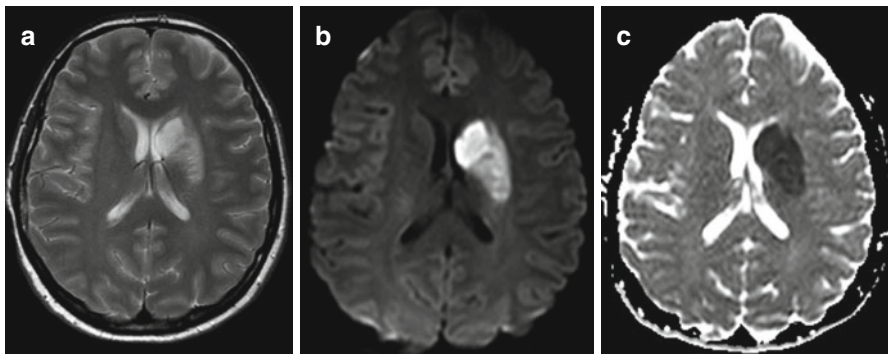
The acute stage of deep striato-capsular infarction. The T2-weighted MR image (a) shows the hyperintense area in the left basal ganglia. The diffusion-weighted image (b) and ADC map (c) show the restriction in diffusion in this area defined as the infarction
